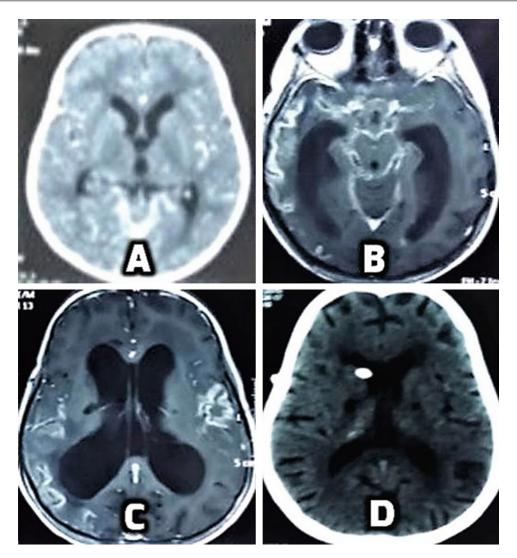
Hydrocephalus developing in a patient treated successfully with a ventriculoperitoneal shunt (a) Axial post-contrast CT showing basal exudates without hydrocephalus (b and c) Axial post-contrast MR image showing
